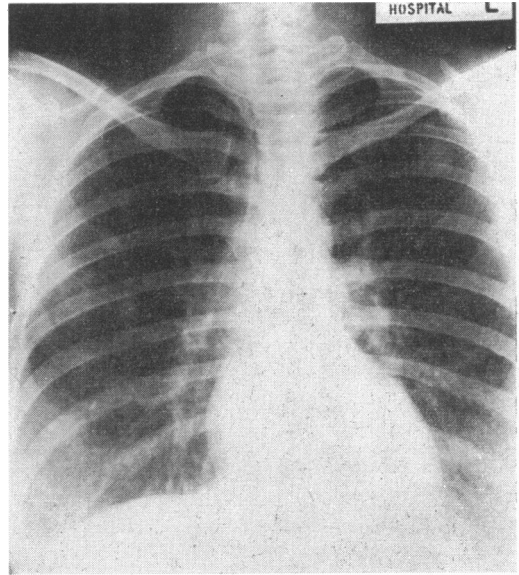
Case 1 Radiograph of chest, November 1959, showing further round shadows in both lungs
